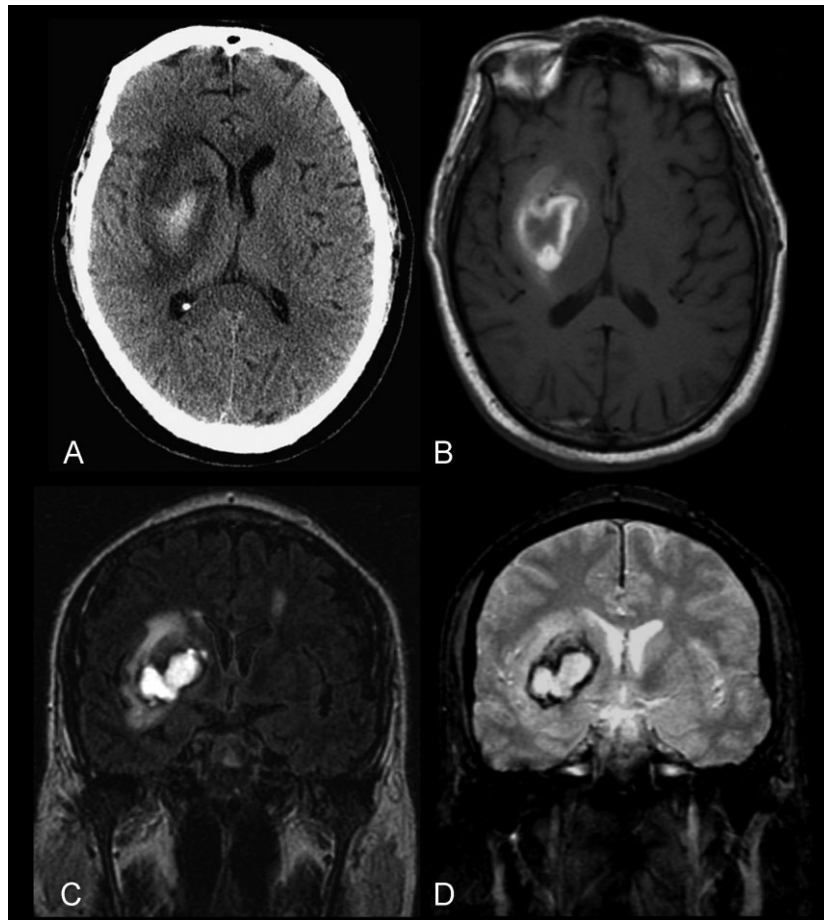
Intracerebral hematoma. (A) The axial computed tomography image shows a hyperdense lesion within the right putamen. The surrounding low attenuation is due to vasogenic edema. (B) On the T1-weighted image, the periphery of the hematoma is hyperintense because of the presence of methemoglobin. (C) The hematoma is also hyperintense on the fluid attenuated inversion recovery image. (D) The gradient-echo T2*-weighted image shows a surrounding hemosiderin rim, which is dark because of local magnetic susceptibility inhomogeneity. Reprinted with permission from *Seminars in Roentgenology*.⁴⁵ Copyright 2006, Elsevier.
